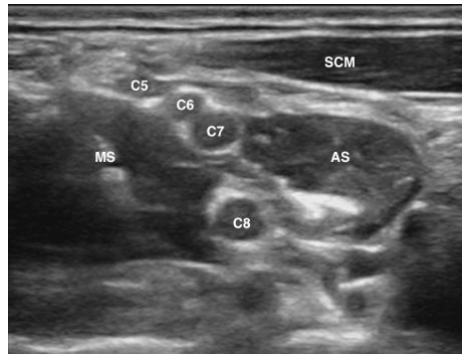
Ultrasound imaging demonstrating location of C5-C8 nerve roots relative to surrounding sternocleidomastoid (SCM), middle scalene (MS) and anterior scalene (AS) musculature.
